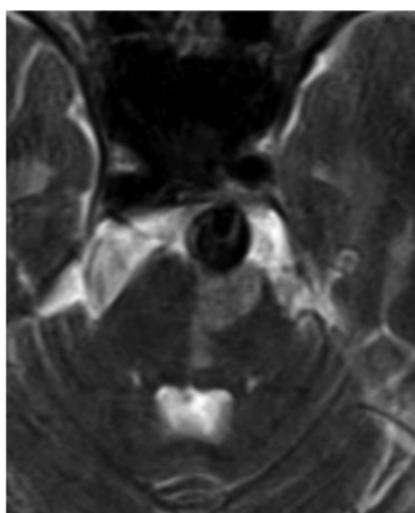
MRI T2 image showing multiple lumens in Basilar trunk. Left median pontine infarction is also shown.
